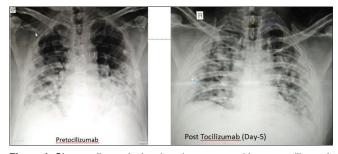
Chest radiograph showing air space opacities pre tocilizumab in bilateral mid and lower zones and clearing of opacities in radiograph five days after tocilizumab administration
